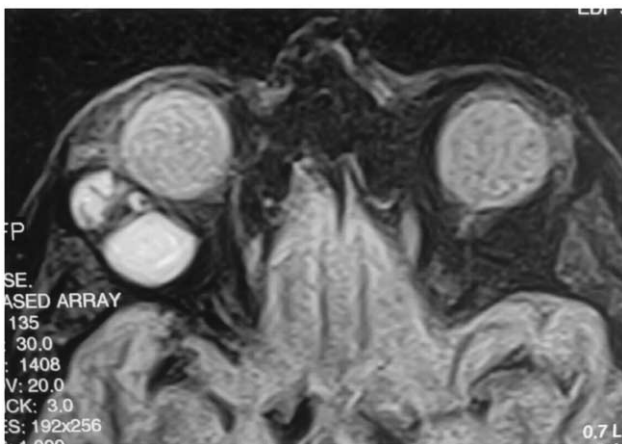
Magnetic resonance imaging shows a multicystic mass.
